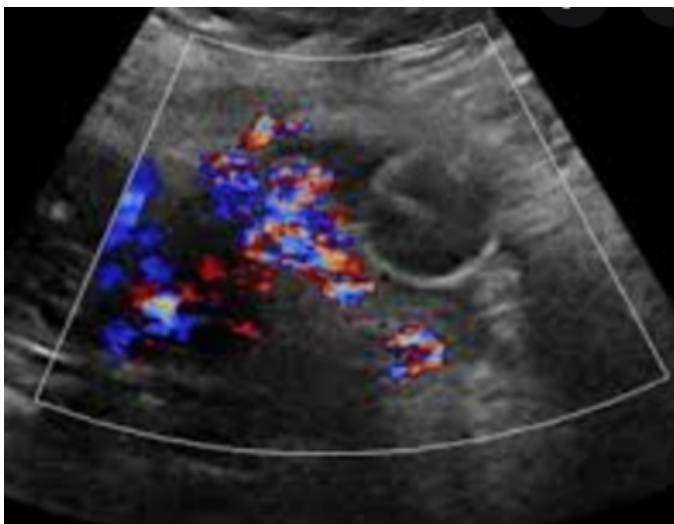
Doppler Ultrasonography showing Placenta Accreta
